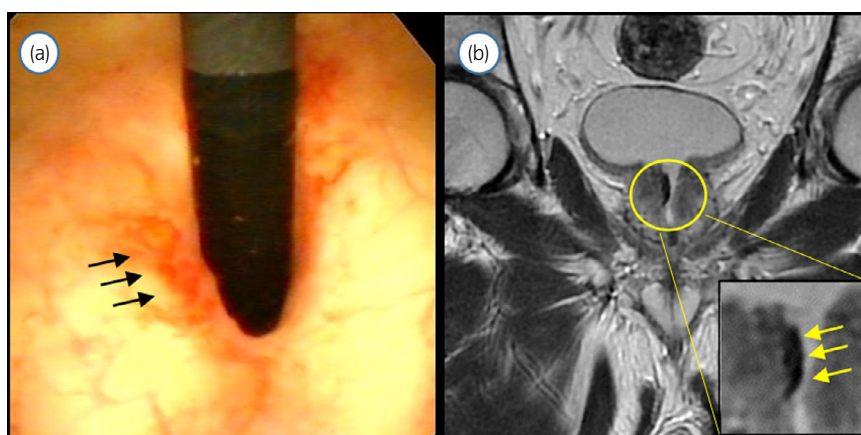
(a) Cystoscopy showed an erythema on the bladder neck before TUR of the mucosa with erythema. (b) T2-weighted MRI showing a 12-mm lesion with low intensity on the bladder neck.
